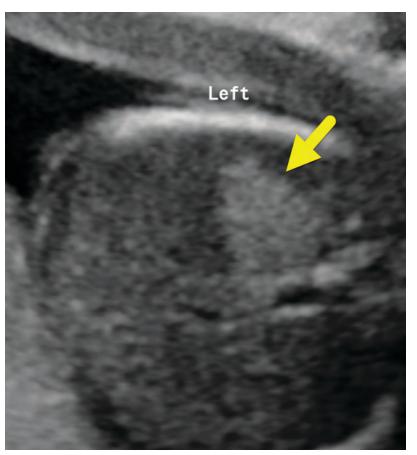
Prenatal ultrasound shows a well-defined echogenic lesion (arrow) in the left lung.
